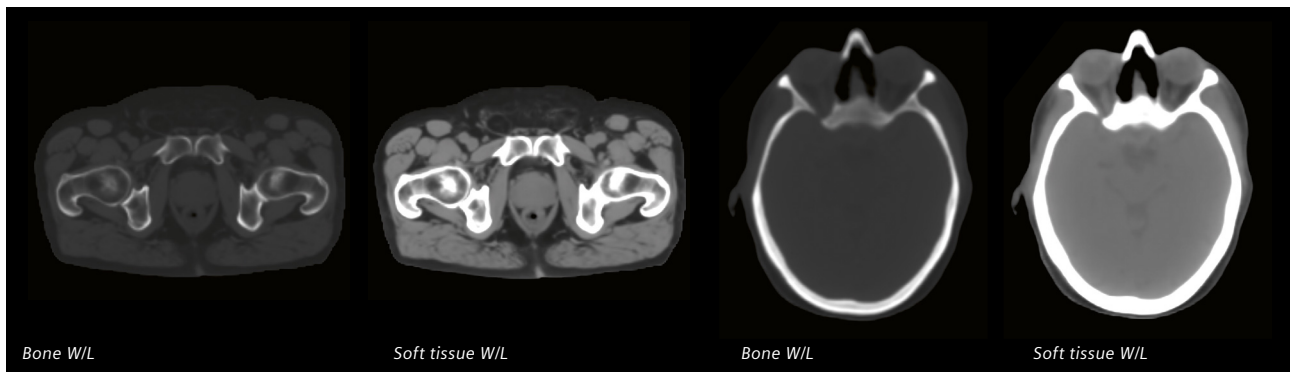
Synthetic CT for the pelvis and brain in two different window levels (W/L): bone and soft tissue.
